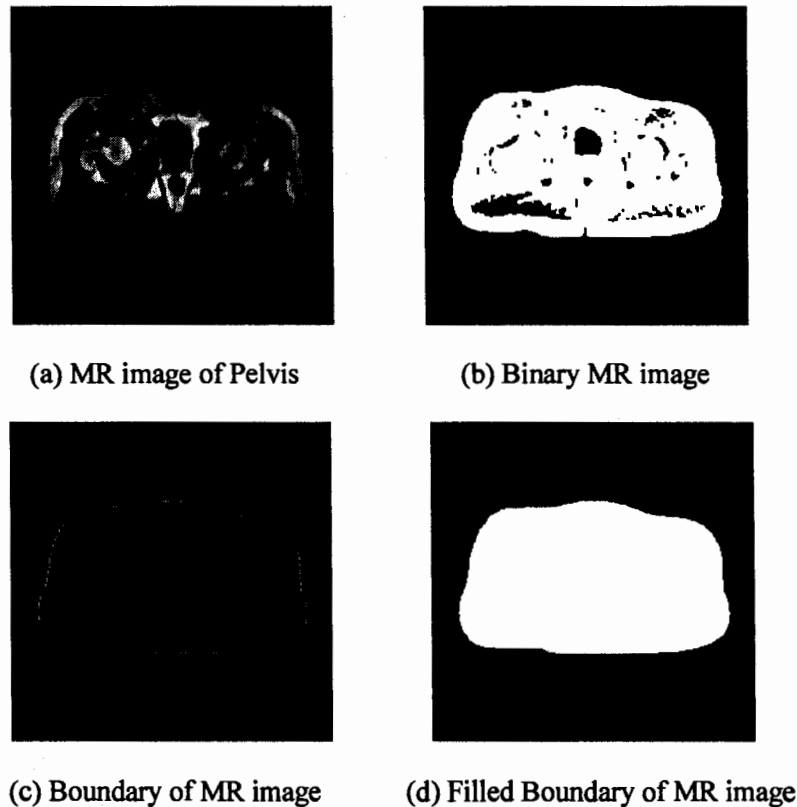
Steps to make foreground as a single region in MR image of Pelvis
